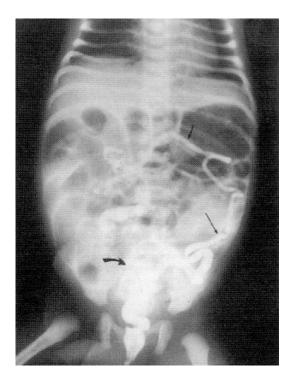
Plain x-ray babygram, supine position, in 3-day-old baby with complicated mechonium ileus. A well-localized globular air (arrows) and fine calcifications is noted.
